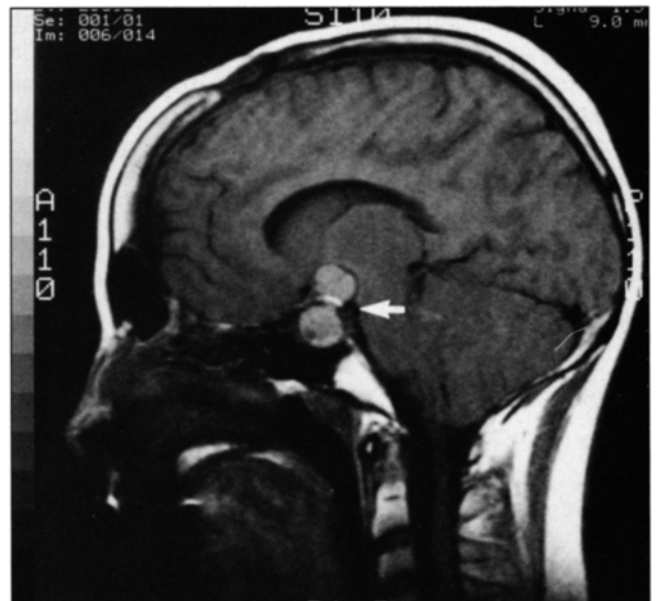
Sagittal magnetic resonance image at the midline showing dumbbell-shaped cystic tumor (arrow).
